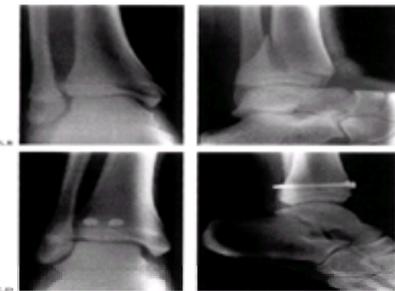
Two-part triplane fracture. A: The anteroposterior radiograph shows a Salter-Harris type III fracture. In this instance, the fracture line does not come out in the intraarticular portion, but exits in the medial distal epiphysis. B: The lateral radiograph shows what appears to be a Salter-Harris type II fracture of the distal tibia. Despite closed manipulation, improvement in alignment could not be obtained, and open reduction and internal fixation were performed. C: The anteroposterior radiograph shows anatomical alignment and the placement of distal metaphyseal screws. D: The lateral view shows reduction of the displaced fracture.
